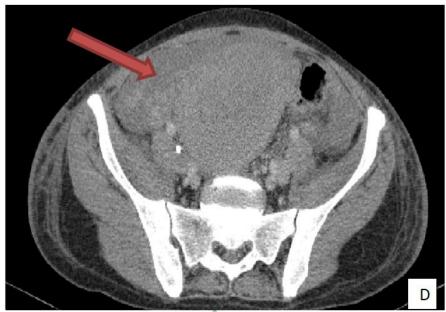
Post Contrast CT scan in axial views (C; D); sagittal view (E) demonstrates: A subscapular hematoma of the liver and moderate hemoperitoneum
